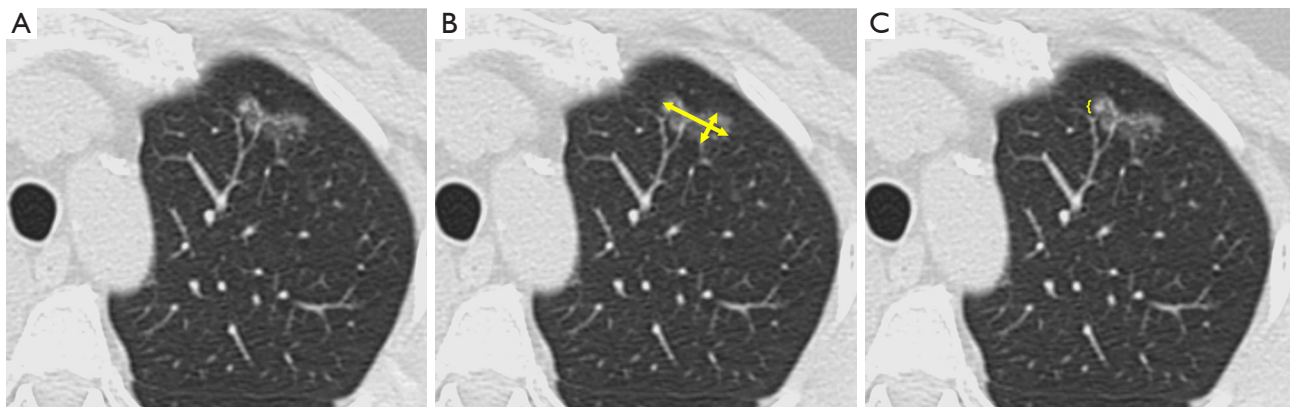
The assessment of an incidental part-solid nodule on CT image. (A) Axial CT images of a part-solid nodule in the left upper lobe. (B) The overall part-solid nodule is measured in the same way as solid nodules. The longest diameter is measured, and the short-axis dimension is also recorded (arrow). (C) The maximal diameter of a solid component should be measured (left curly bracket) and reported if >3 mm. CT, computed tomography.
